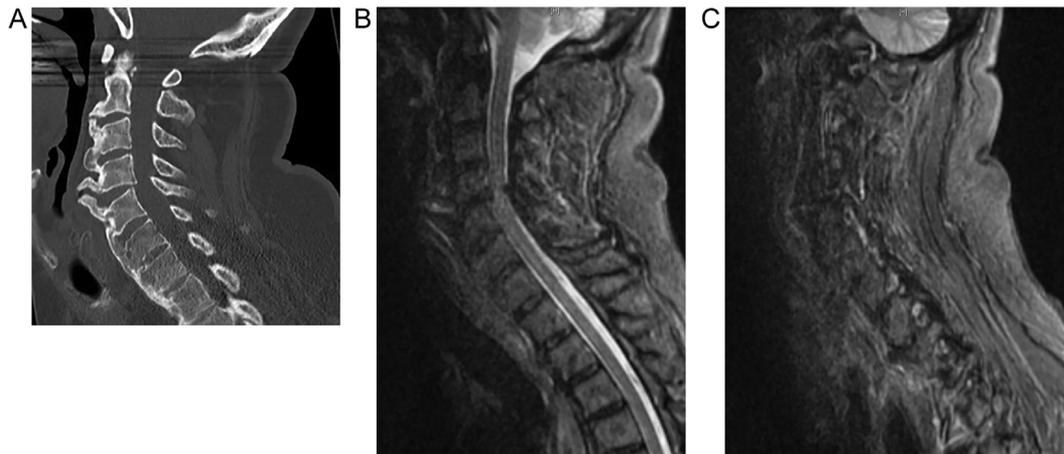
(A) Cervical CT reported a gap between anterior osteophytes with some retrolisthesis of C4 on C5. (B) On the cervical MRI, we can see increased signal in the space between the anterior osteophytes, without increased signal at the disk space. Severe stenosis of the canal at C4–5 level due to mild disk herniation and ligamentum flavum hypertrophy. (C) The C4–5 facets are also mildly widened, with hyperextension at C4–C5.
